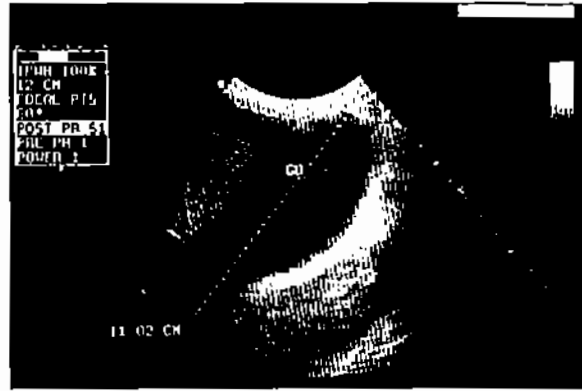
An ultrasonographic study revealed enlargement of the gallbladder (vesica felea hydrops) and obstruction of the distal common bile duct
